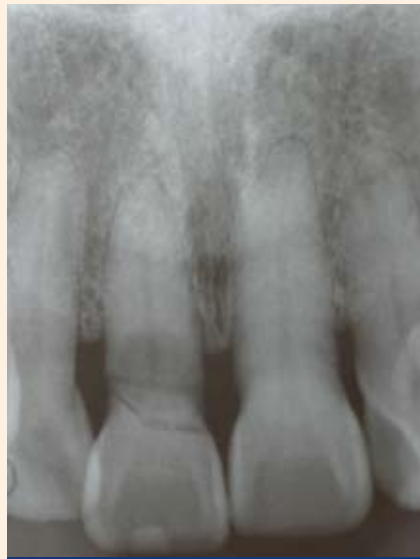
Radiograph of oblique crown and root fracture tooth #8.
